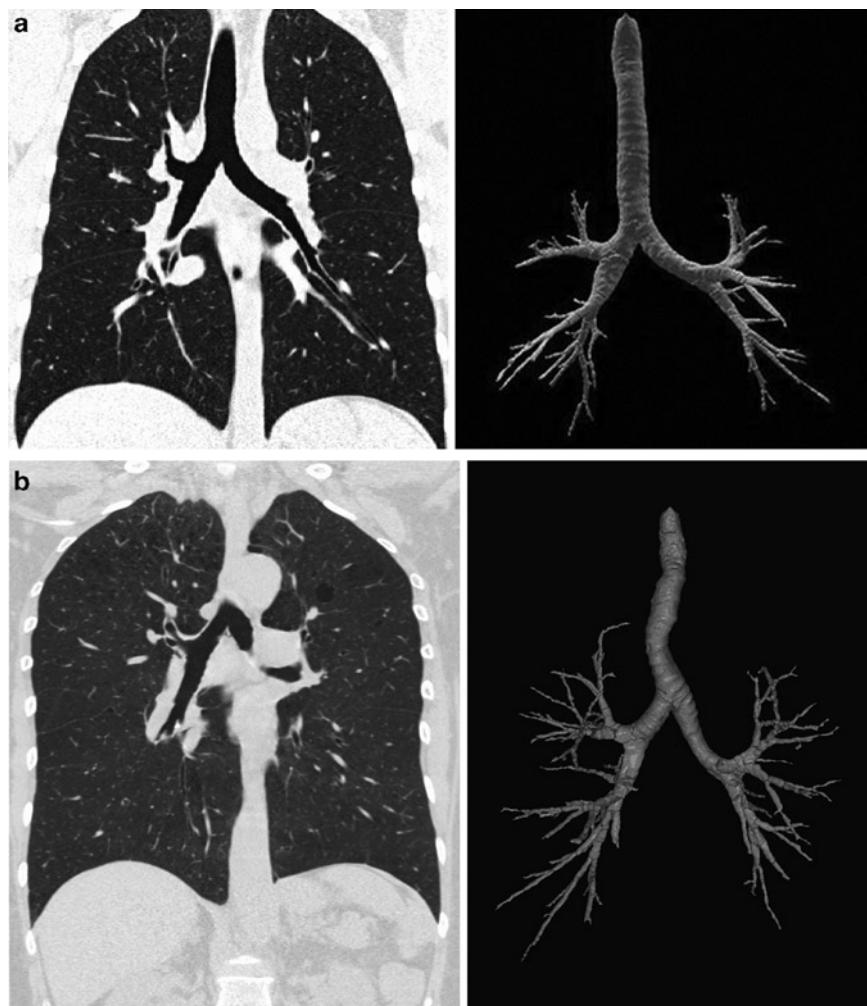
shows a multidetector three-dimensional CT scan of the chest displaying the trachea and bronchial anatomy in a 25-year-old healthy volunteer; Fig. 16.2b shows the changes that occur in a 60-year-old man with severe COPD, which shows a deviated trachea and narrow bronchus. Points of importance include the recognition of any distorted anatomy identified in the films prior to placement of DLTs.
